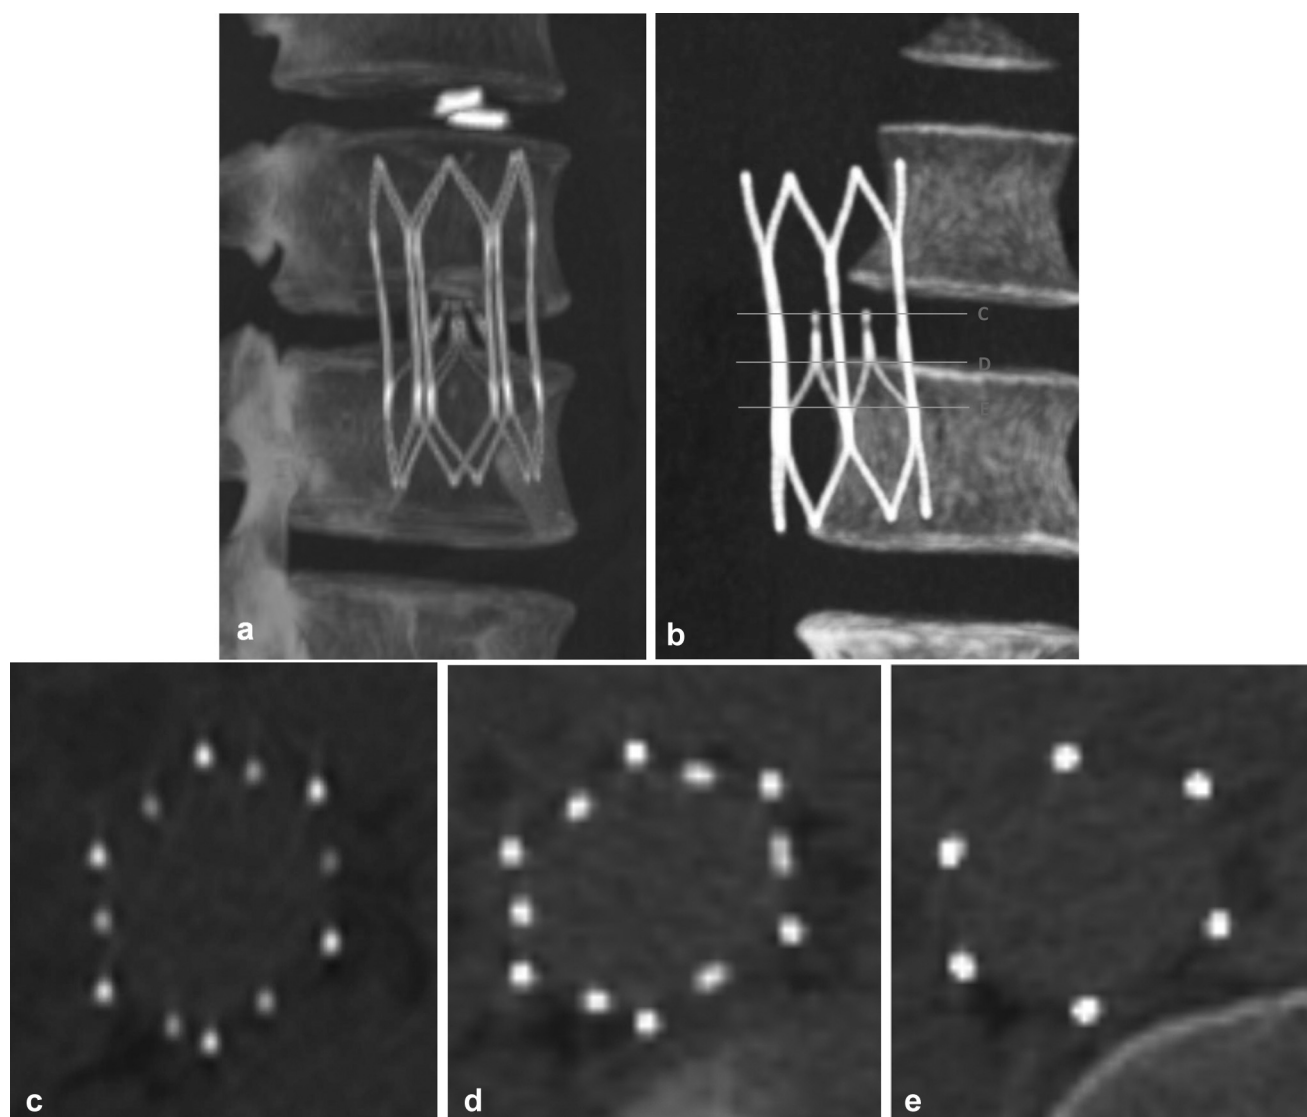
Representative CT imaging for a single patient. (a) Coronal image acquired as part of helical dataset 1 month after filter placement, showing the Sentry device in filtering configuration. (b) Coronal image at 6-month follow-up showing the device in bioconverted configuration. (c–e) Axial views of the bioconverted device at 6-month follow-up, with the images keyed to the coronal view in (b).
